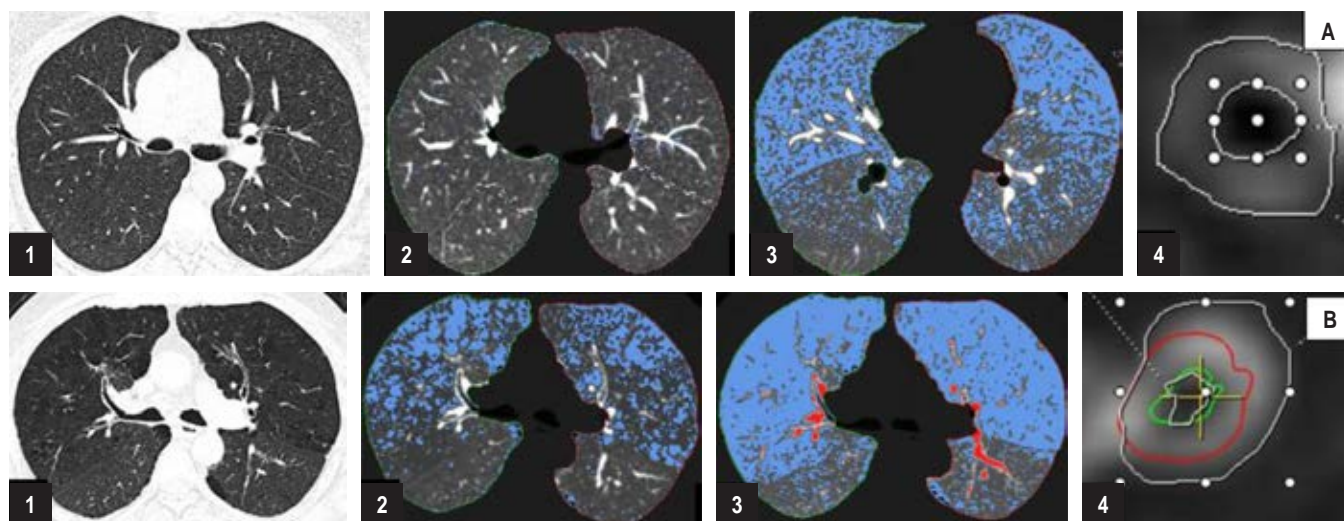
PM CT in patients with COPD and pre COPD secondary to smoking. A) CT scan of an ex-smoker patient with dyspnea without spirometric obstruction is shown: CT findings in A1 a normal high resolution CT scan; in A2 the parametric map (PM) shows a volume of 4,482 mL, emphysema index of 3.4%; in A3 PM in expiratory with air trapping of 43.9%, and airway analysis a percentage of wall area (%AP) in A4 of 0.80. His PFTs are characterized by air trapping on body plethysmography (RV/TLC 142% predicted). B) Shown is a CT scan of a patient with GOLD 2 COPD due to smoking, dyspnea mMRC2: with centrilobulillar and paraseptal emphysema pattern in B1; PM in B2 with volume of 6,558 mL, emphysema index of 21.9; MPR B3 with air trapping of 56.8% and airway analysis with %AP in B4 of 0.93. His PFRs are characterized by air trapping on plethysmography (RV/TLC 161% predicted, adjusted DLco 57% predicted).
